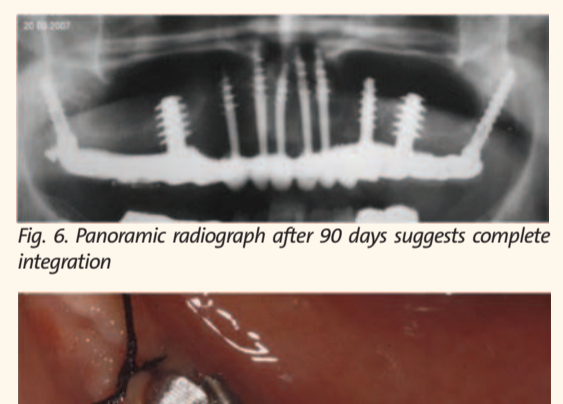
Panoramic radiograph after 90 days suggests complete integration
